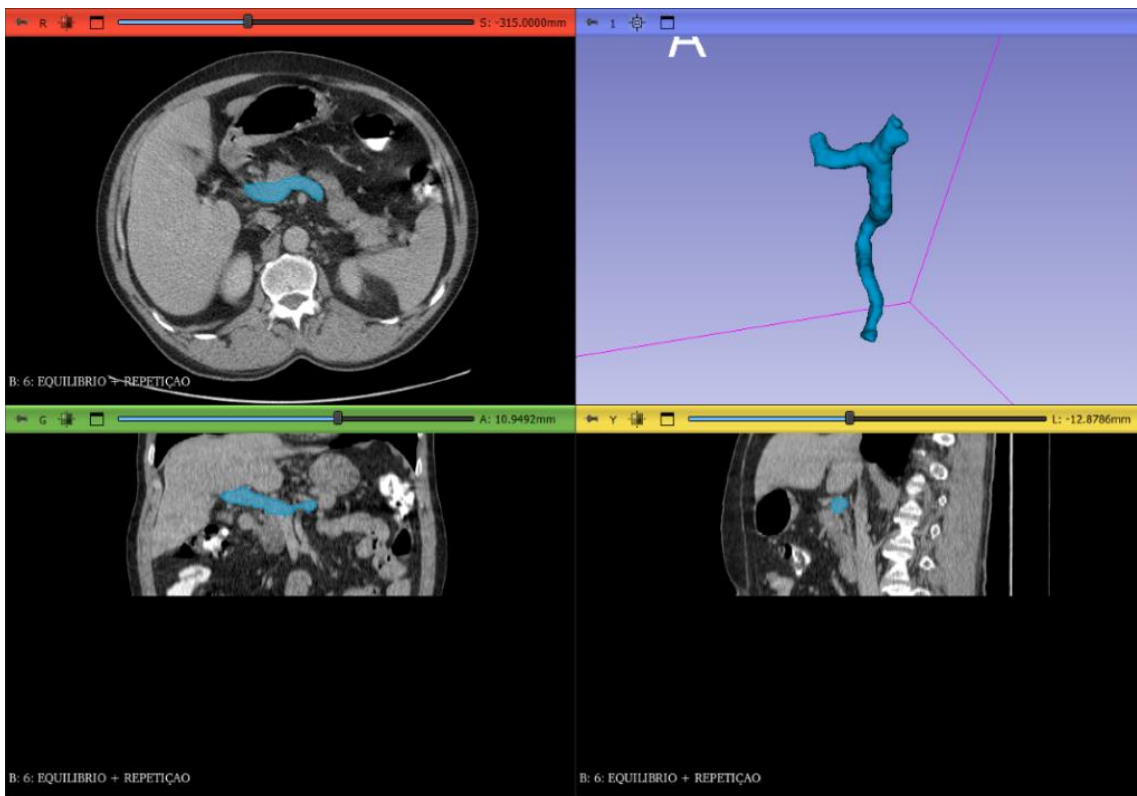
CT scan images (axial, coronal, and sagittal) of a male patient with gallbladder carcinoma and the generated 3D model.
